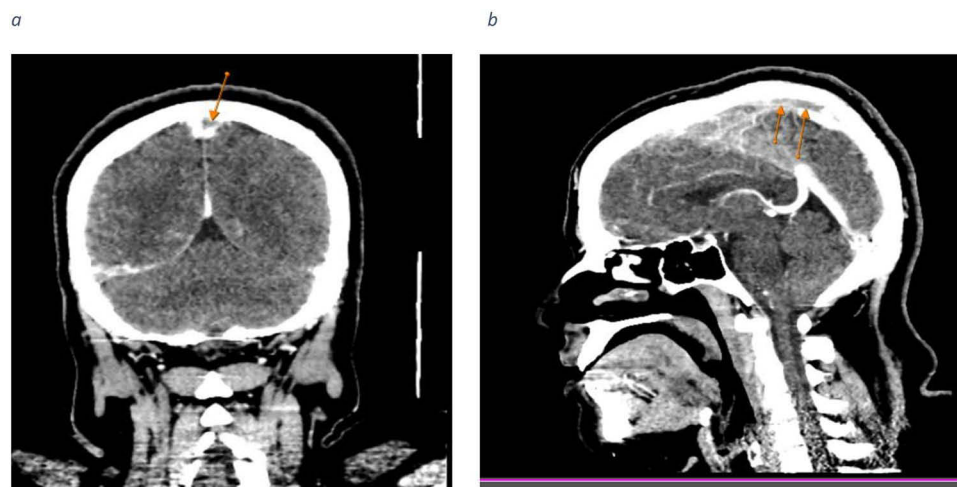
(a) Coronal contrast-enhanced CT scan of the brain reveals a filling defect along the superior sagittal sinus, presenting as a delta sign (indicated by an arrow). (b) Sagittal contrast-enhanced CT scan of the brain displays a tubular filling defect along the posterior aspect of the superior sagittal sinus (highlighted by an arrow).
